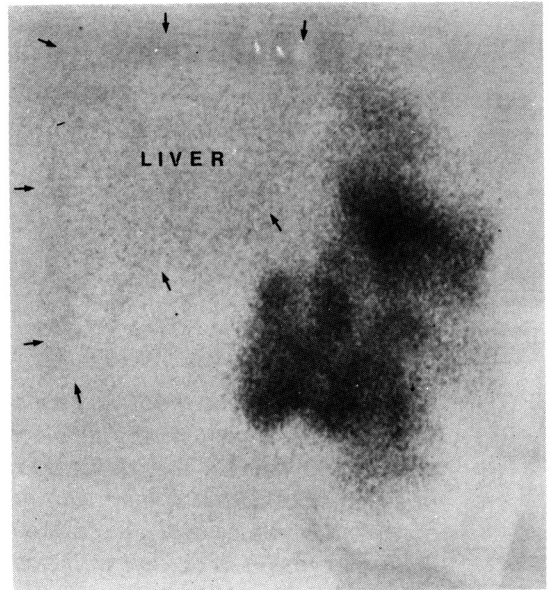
Anterior view from selective spleen scintigraphy shows a large spleen with multiple defects in the parenchyma and peripheral zone. (Liver is indicated by small arrows.)
